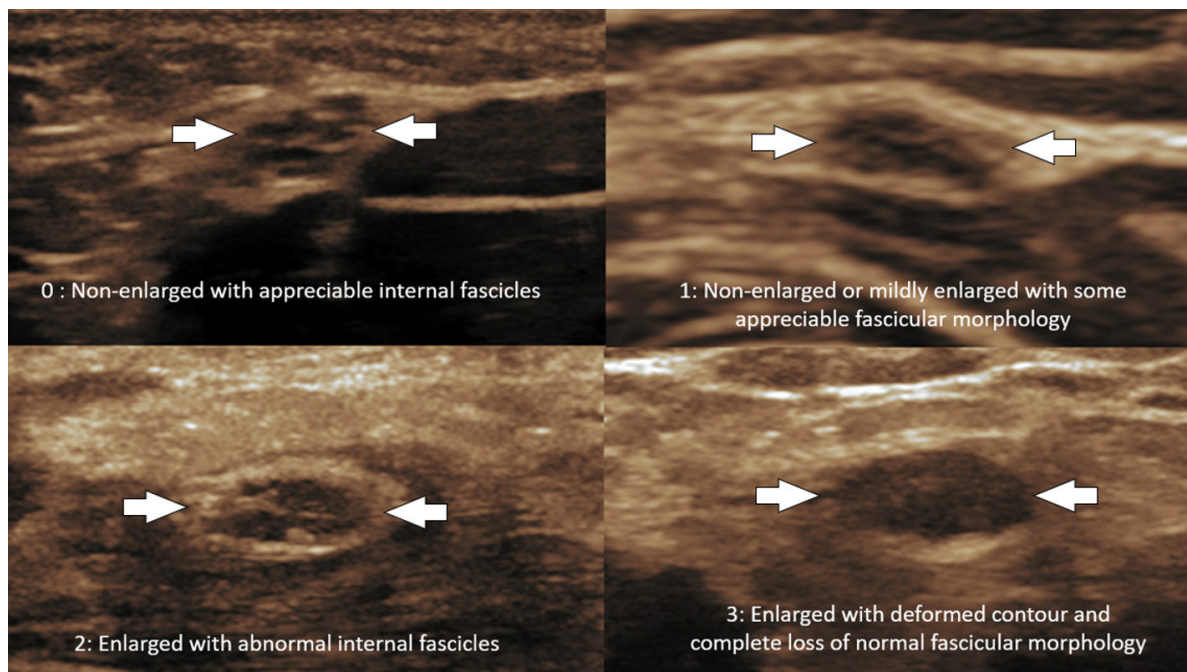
Grading system for ultrasound imaging evaluation with transverse images of the ulnar nerve (white arrows). 0 – Non-enlarged nerve with preserved echogenic internal fascicles. 1 – Non-enlarged or mildly enlarged nerve with low-grade (<50%) loss of normal fascicular morphology. 2 – Enlarged nerve with deformed nerve fascicles and partial loss (>50%) of normal fascicular morphology. 3 – Enlarged nerve with deformity/constrictions and complete loss of normal fascicular morphology
